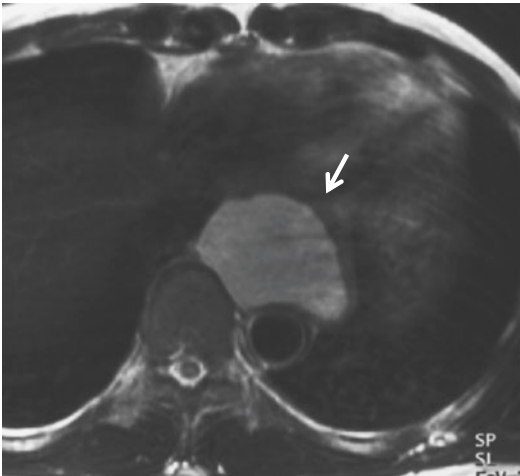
Bronchogenic cyst. T2-weighted axial MR image (arrow) shows a mass at the paravertebral region of intermediate signal intensities suggesting proteinaceous fluid
